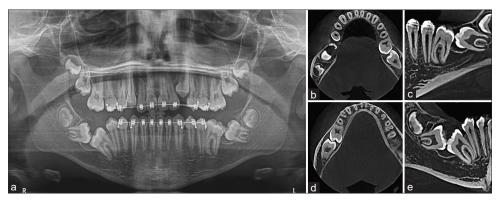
(a) Panoramic radiograph showing the overall condition; (b and d) CBCT axial slice; (c and e) vestibule-lingual CBCT showing the angulated position of the molars, the increase in the pericoronal follicle and small calcifications near the crown of these teeth. CBCT: Cone-beam computed tomography
